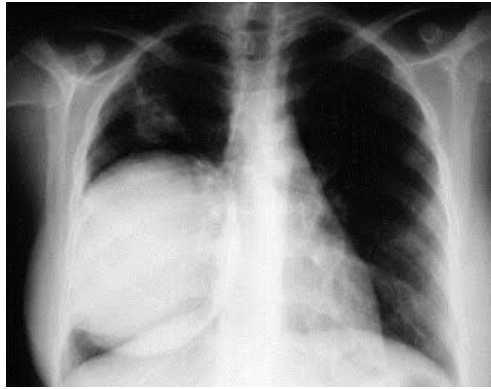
Chest x-ray A large right basic thoracic opacity
